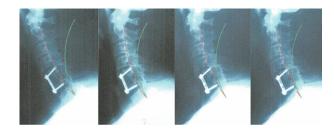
Initial and follow-up lateral cervical radiographs. A: 7-21-04; B: 9-27-04; C: 1-15-05; D: 3-12-07. Note at C5–C6 the evidence of an anterior plate and autologous iliac crest bone graft. The green line represents ideal cervical lordosis, the red line highlights patient.
